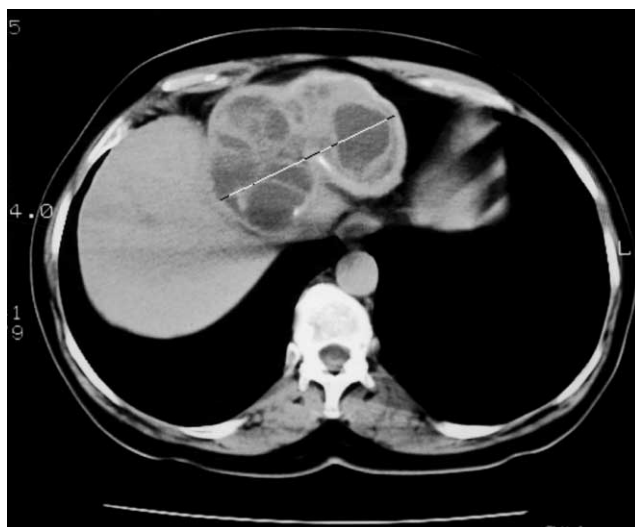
Abdominal CT demonstrated multilocular septated cyst in the left liver lobe.
